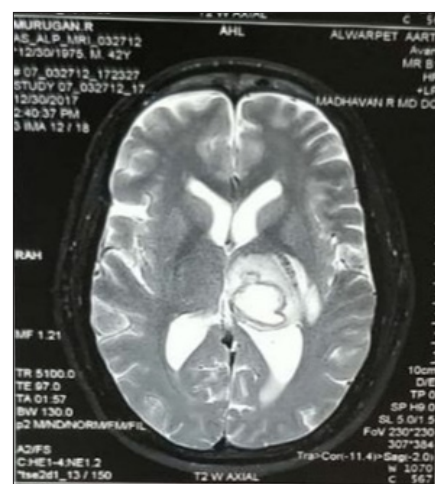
MRI Brain revealed Well-defined Peripherally Enhancing Multilocular Lesion involving the Left Thalamus causing Effacement of Atrium of Left Lateral Ventricle
